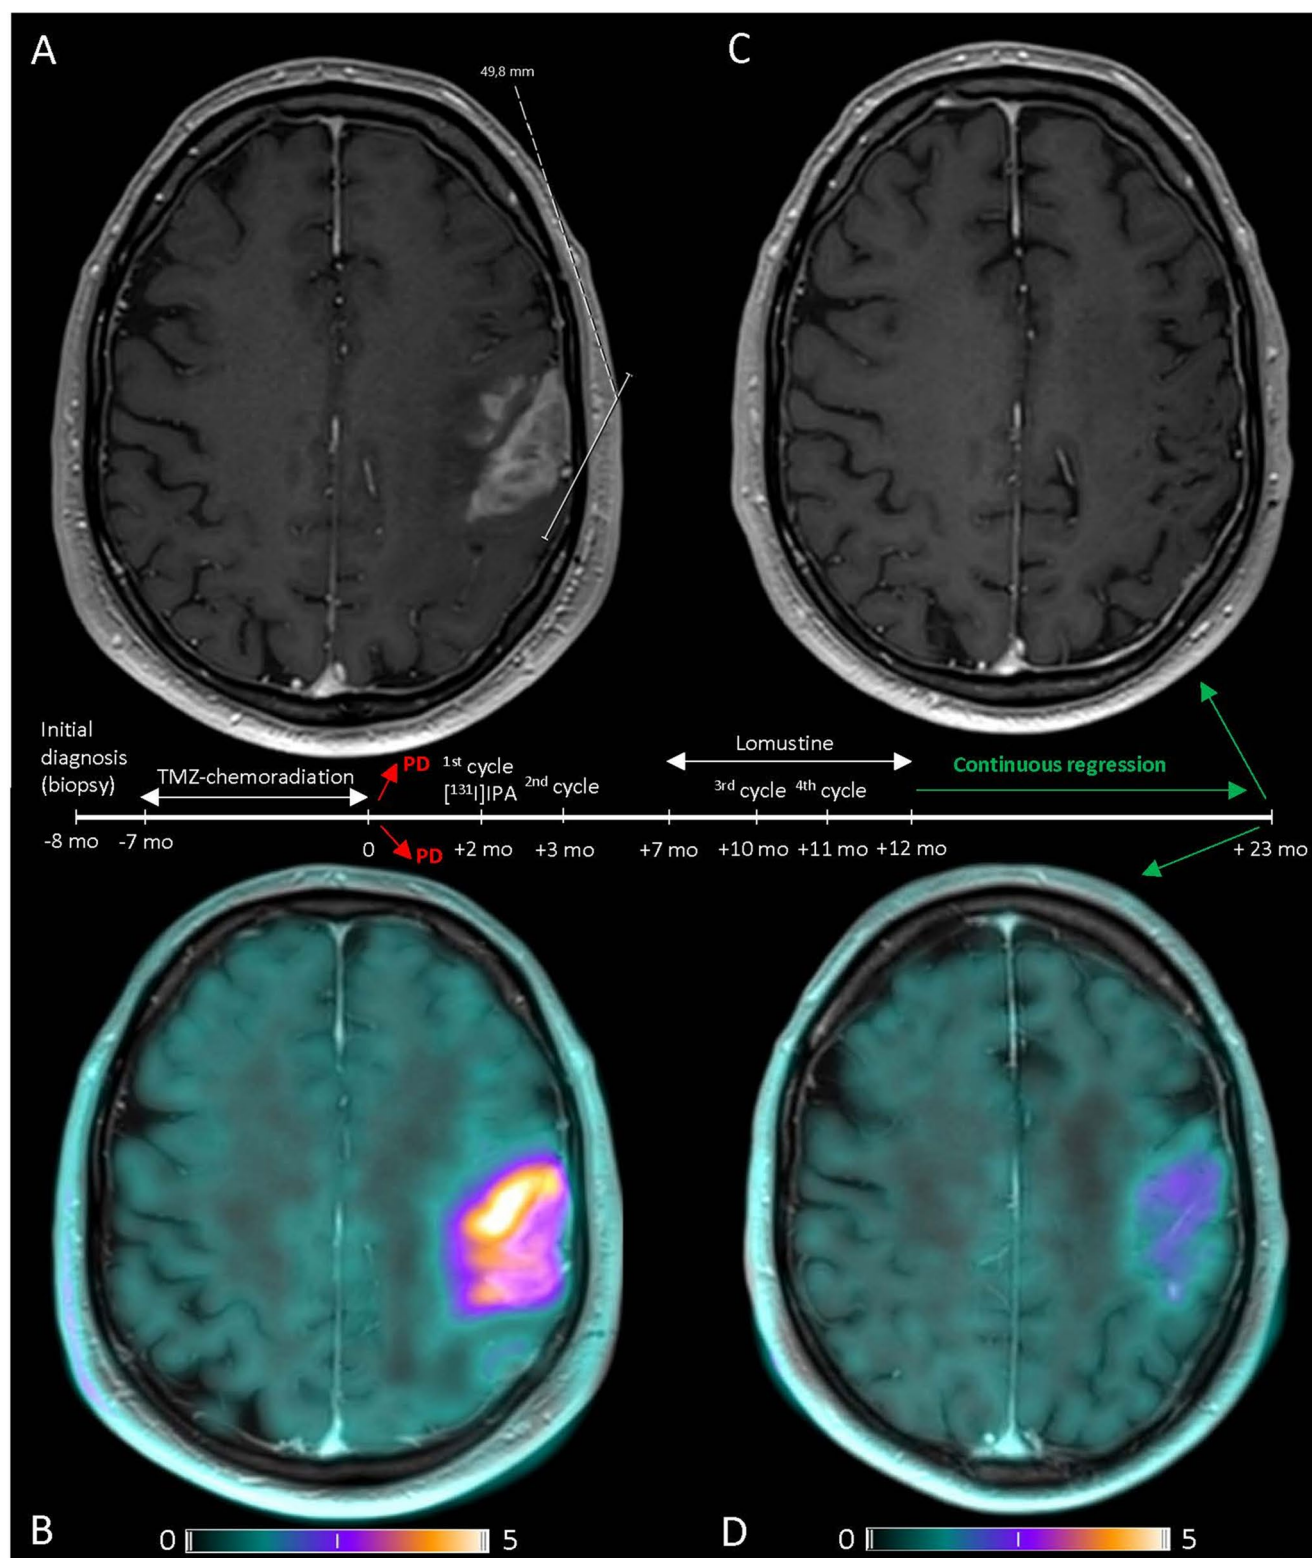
Timeline and imaging response of recurrent glioblastoma after combined $[^{131}\text{I}]$ IPA and lomustine. A Pre- $[^{131}\text{I}]$ IPA gadolinium-enhanced T1-weighted MRI (gdMR) demonstrating recurrence of a glioblastoma in the left parietotemporal lobe with a maximum diameter of 49 mm. B Pre- $[^{131}\text{I}]$ IPA $[^{18}\text{F}]$ FET-PET/CT revealing pathological uptake with a maximum tumor-to-background ratio (TBRmax) of 5.6, confirming tumor recurrence and validating the patient's eligibility
